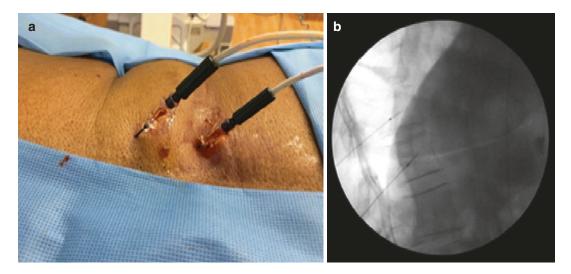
(a) The lateral fluoroscopic view shows the placement of the two needles placed at T11 and T12 (b) with corresponding X-ray. (From Kapural and Jolly [45], with permission)
